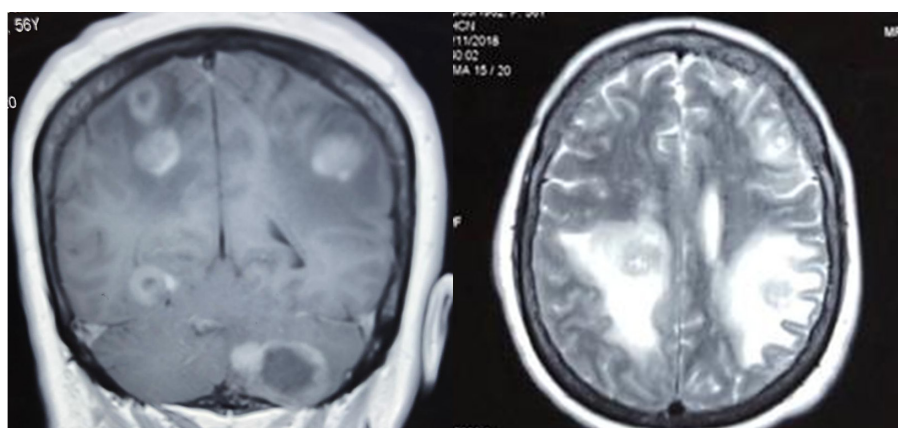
Magnetic resonance imaging of a patient with multiple brain metastases. Axial T2 slice sequence shows perilesional edema in the junction of white and gray matter
